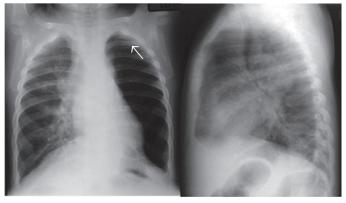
Chest X-ray AP:Left lung hyperlucent with decreased pulmonary vascularity.
